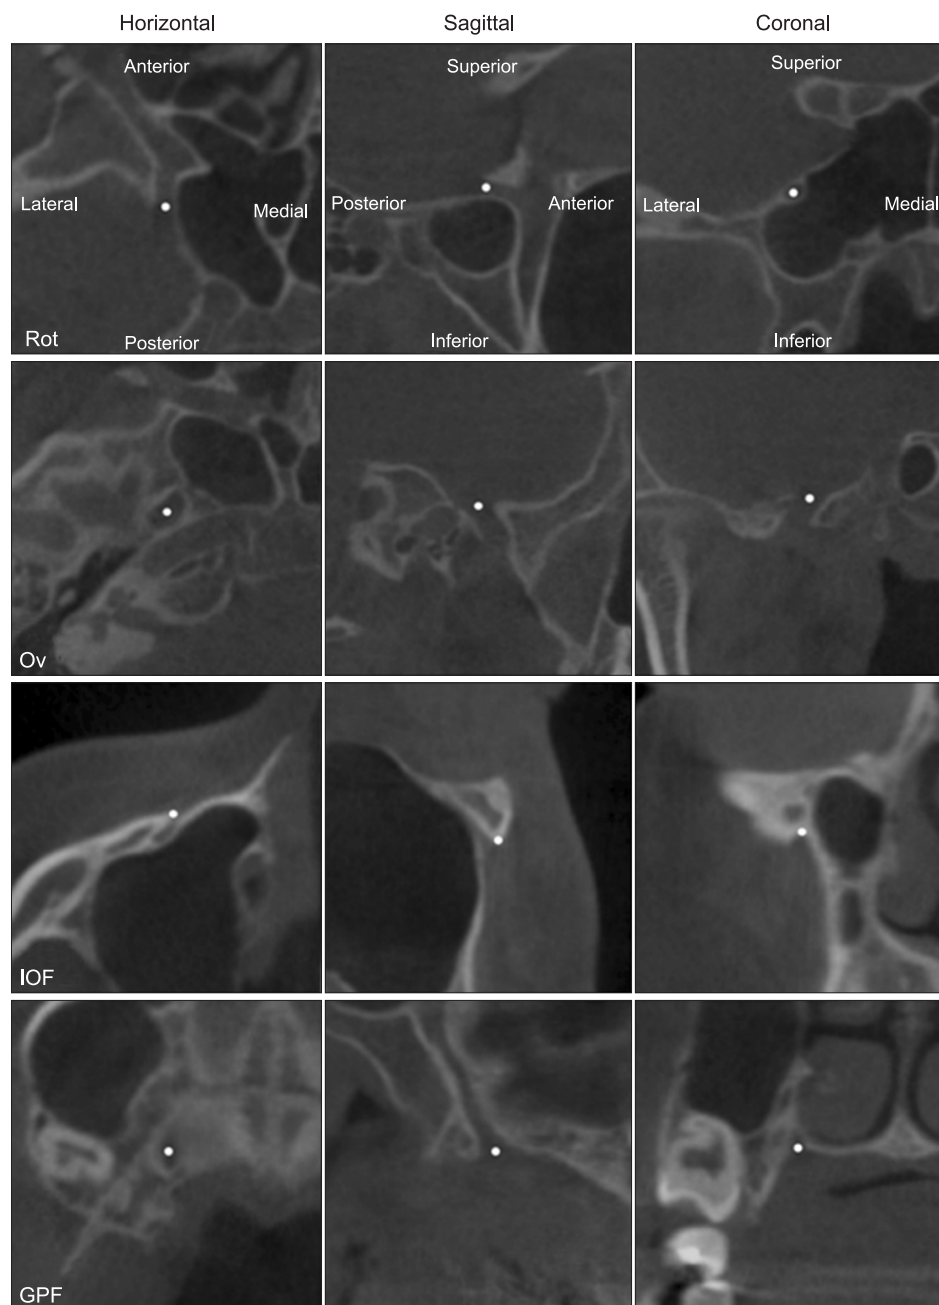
Description of landmarks in cone-beam computed tomography images. The images in each column have the same orientation as the corresponding images in the first row.
